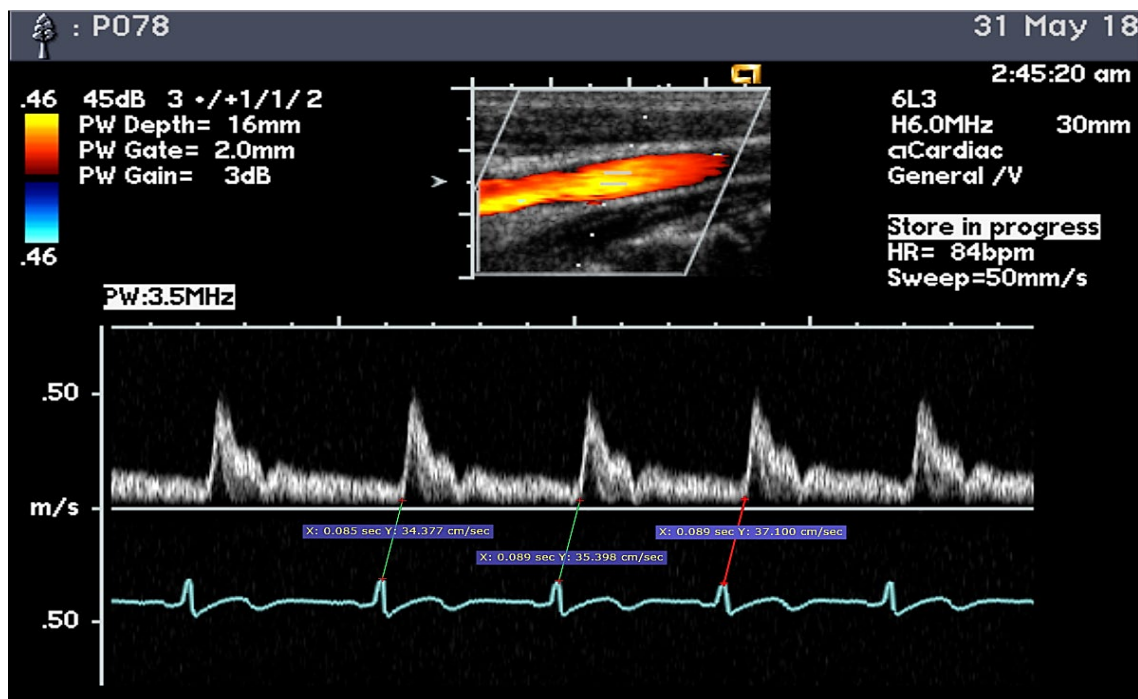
Doppler of the pulse wave at the common carotid artery
